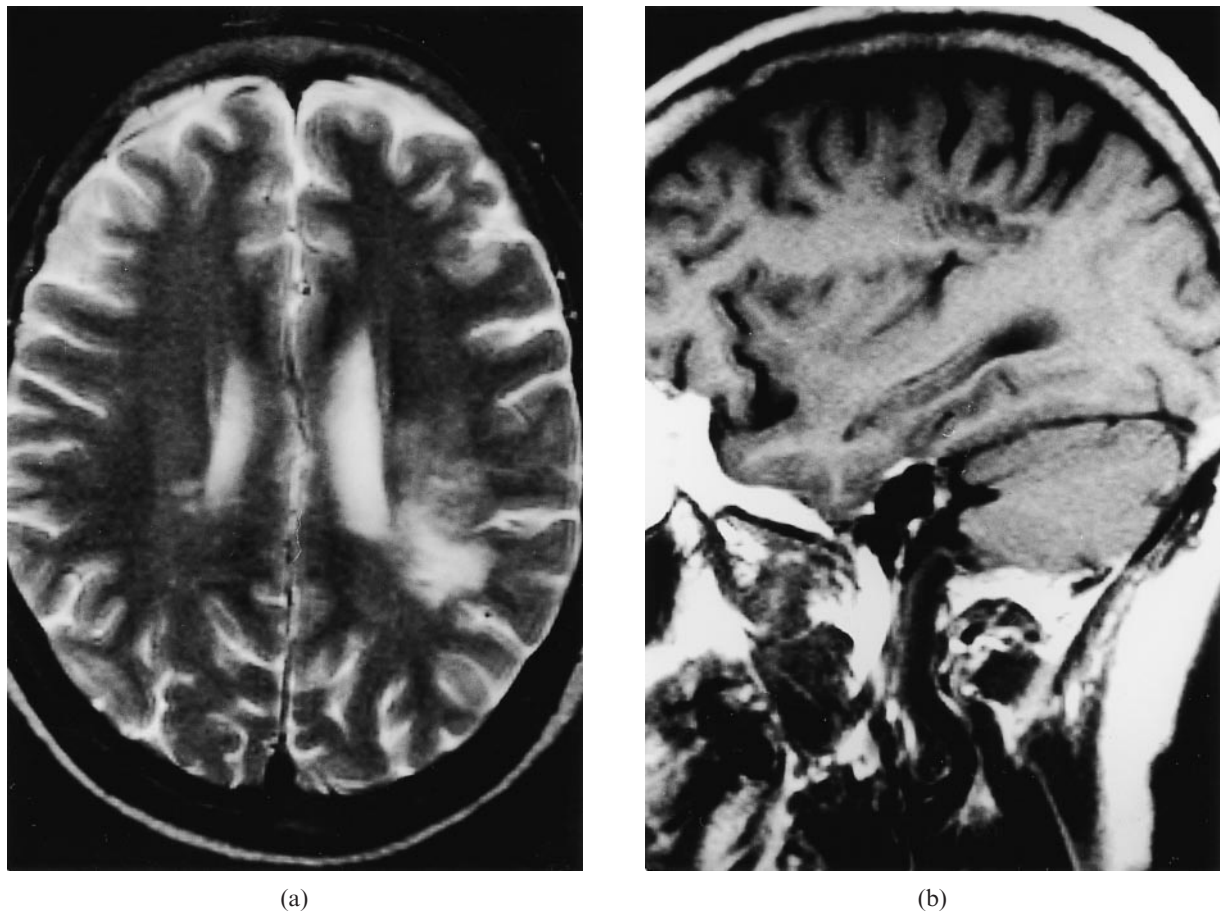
Follow-up MRI 12 months later. (a) Axial T_2 weighted image and (b) sagittal T_1 weighted image show that the concentric pattern of the left parietal lesion is still present.
